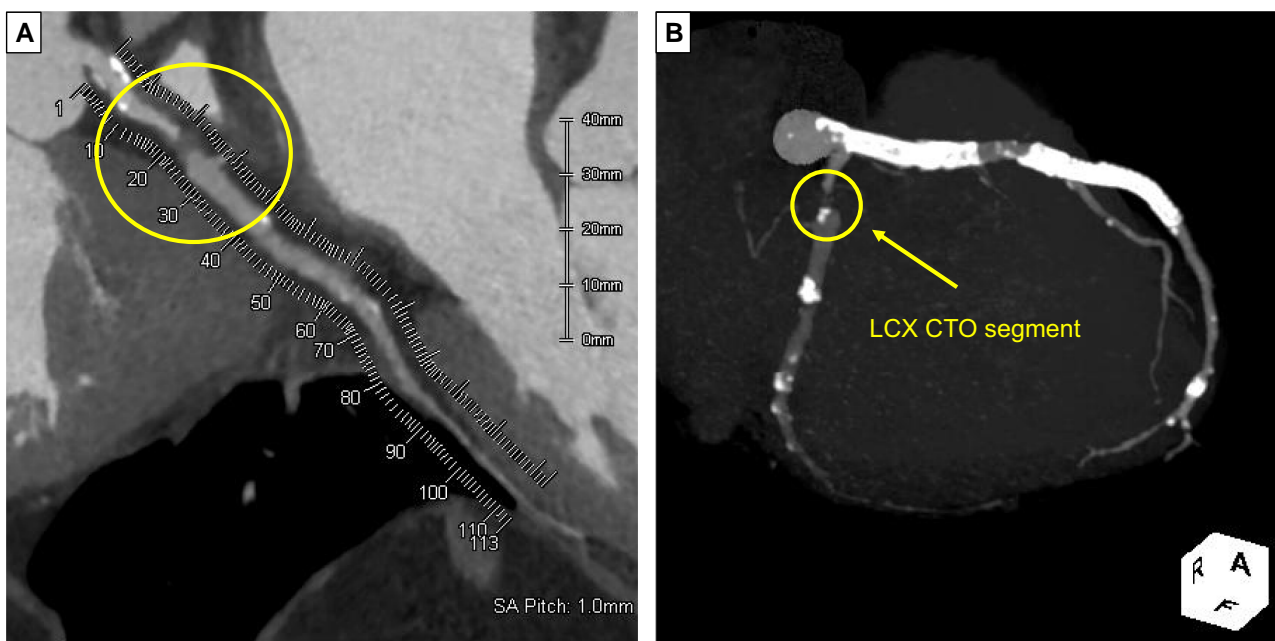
(A) Curved planar reconstruction image of pre-procedural coronary computed tomographic angiography shows a short occlusion length of chronic total occlusion of the left circumflex coronary artery. (B) Maximal intensity projection image of pre-procedural coronary computed tomographic angiography.
